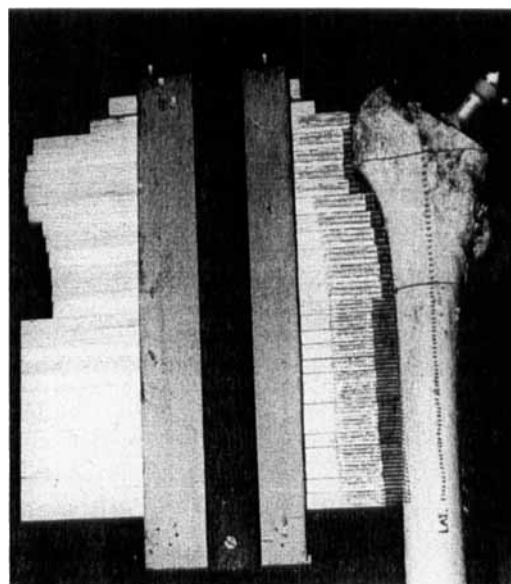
Marking device that can be contoured to the femur. A row of sliding boards, each of which carries three pins at the end, is radiographed alongside the femur. The pins will appear on the film, flanked by parallel lines to be numbered in correspondence with ink marks on the bone.
